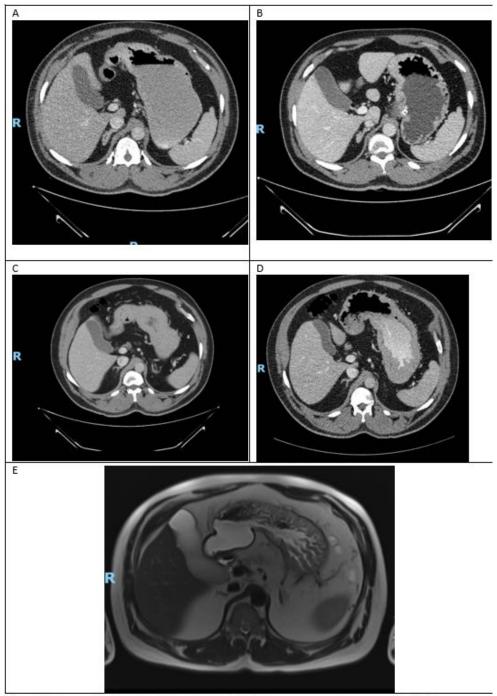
Progression of gastric thickening. A - 6/8/2017 on computed tomography (CT). B - 24/11/2018 on CT. C - 29/11/2020 on CT. D - 9/3/2022 on CT. E - 27/5/2022 on magnetic resonance, T2 weighted.
